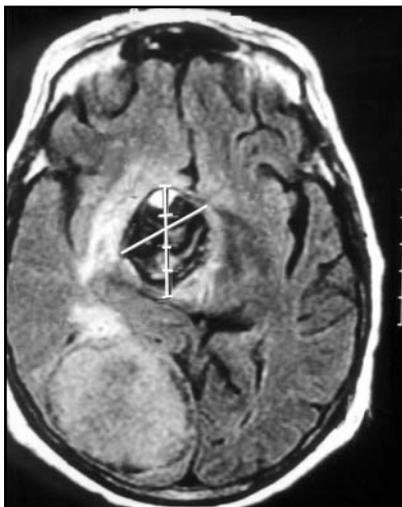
Magnetic resonance imaging confirming the aneurysm growth. The aneurysm's size is 38 mm x 27 mm.
